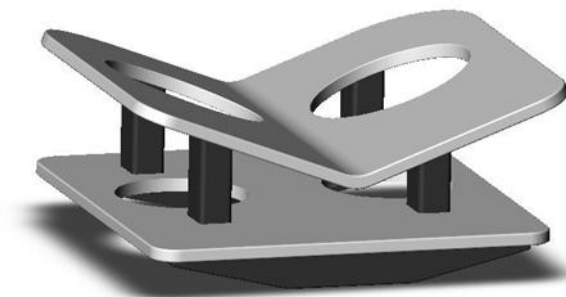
Standard MRI Breast coil
